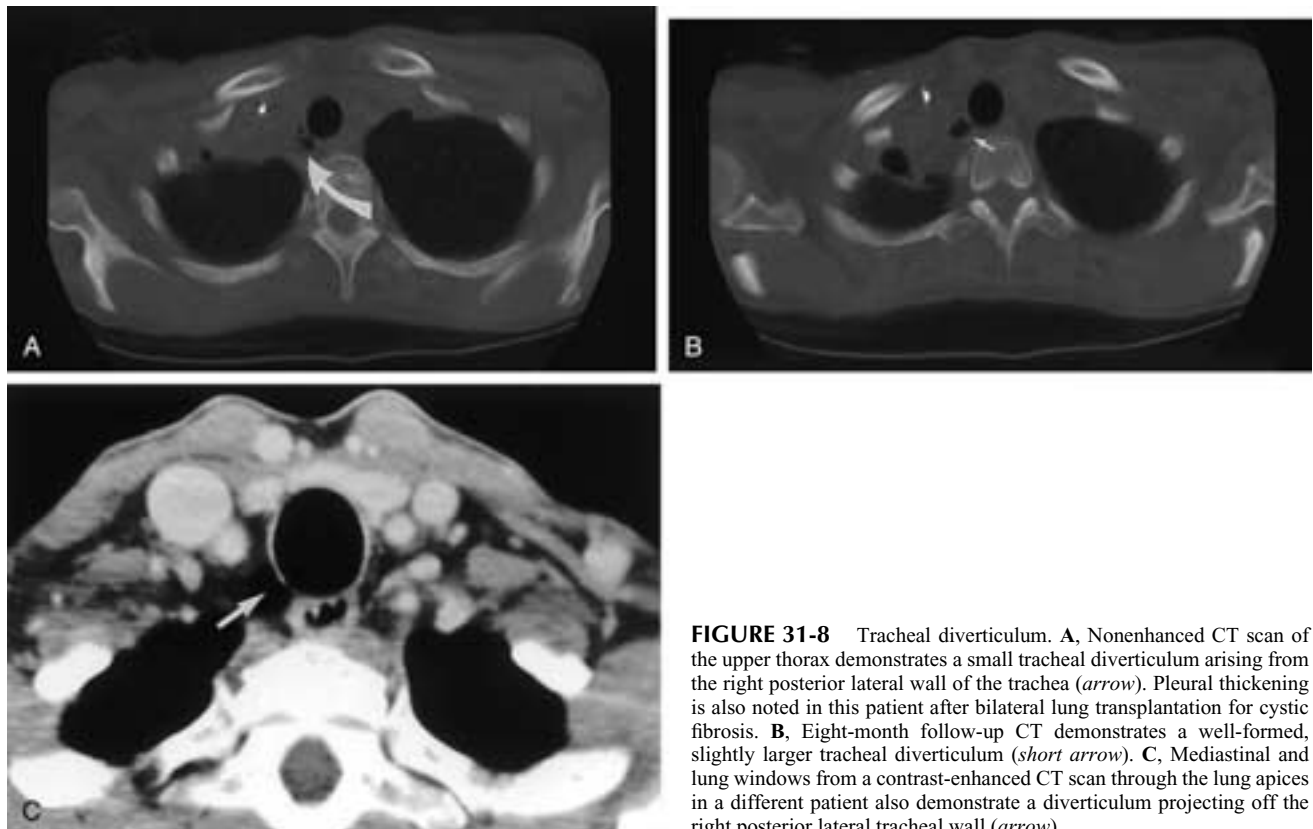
Tracheal diverticulum. A, Nonenhanced CT scan of the upper thorax demonstrates a small tracheal diverticulum arising from the right posterior lateral wall of the trachea (*arrow*). Pleural thickening is also noted in this patient after bilateral lung transplantation for cystic fibrosis. B, Eight-month follow-up CT demonstrates a well-formed, slightly larger tracheal diverticulum (*short arrow*). C, Mediastinal and lung windows from a contrast-enhanced CT scan through the lung apices in a different patient also demonstrate a diverticulum projecting off the right posterior lateral tracheal wall (*arrow*).
